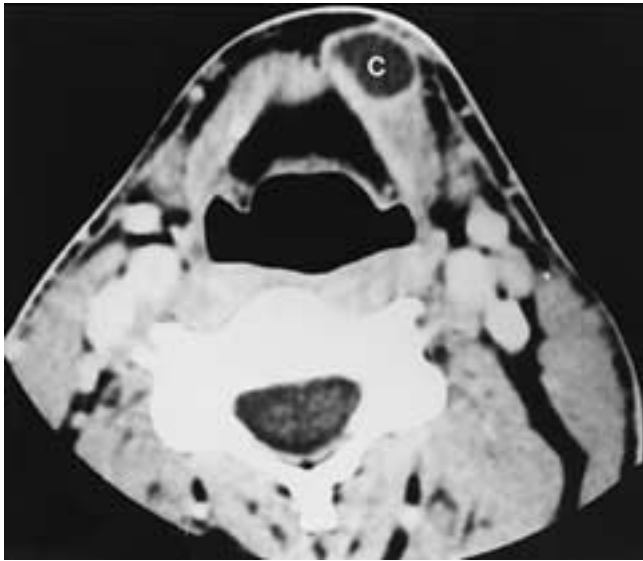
Thyroglossal duct cyst (C) on axial CT. Note that the fat within the larynx is normal. The paraglottic level would be normal as well.
